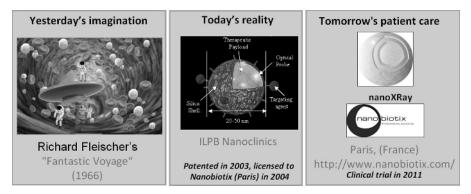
The imaginary nanosubmarine in the 1966 science fiction movie *Fantastic Voyage*, shown with the concept of a nanoclinic developed by us in 2002. This technology is currently being used in a clinical trial at Nanobiotix for X-ray nanotherapy.
